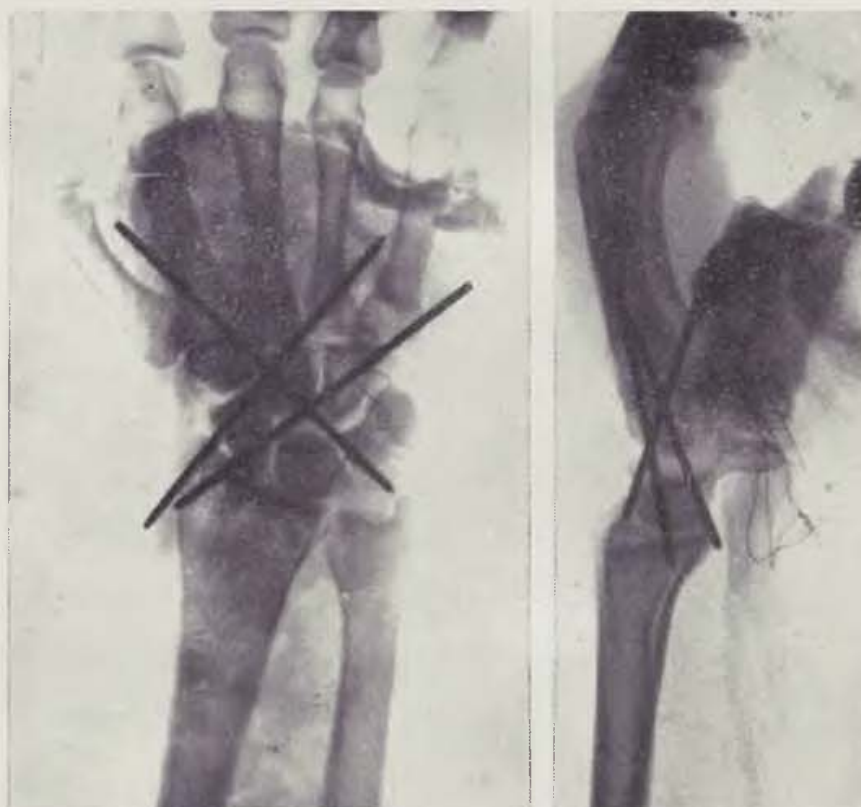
X-ray after the intervention. The Kirschner wires for bone fixation are visible, as well as the two wires used for tendon suture
